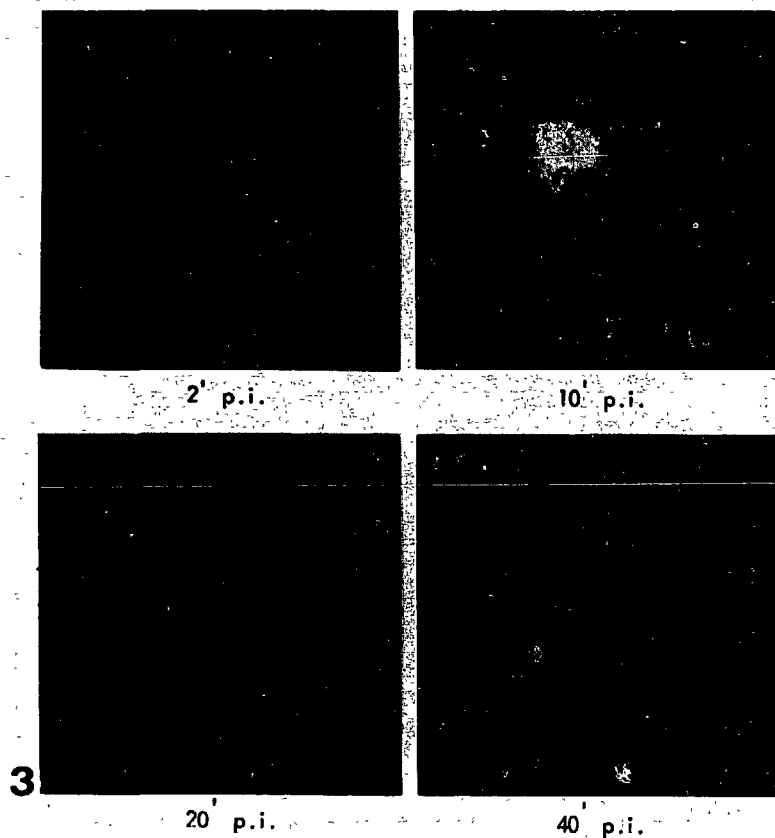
Serial scintigram of a normal individual.
